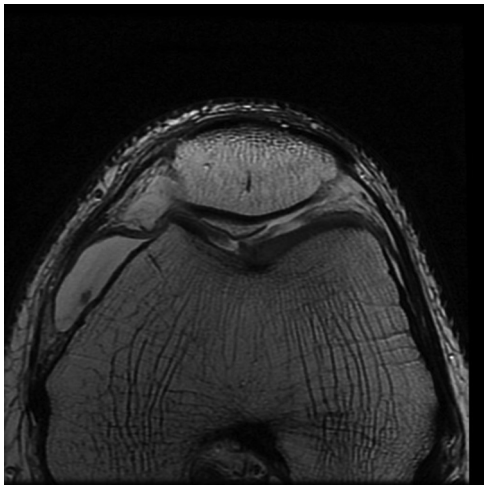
Axial section of a follow-up magnetic resonance imaging.
